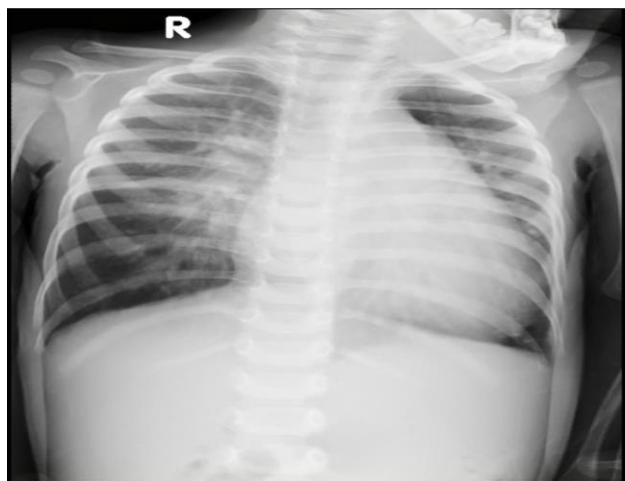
The Chest X-Ray Examination Indicates Cardiomegaly, A Prominently Visible Conus Pulmonalis with Heterogeneous Consolidation in Both Lung Fields Suggests A Condition of Pulmonary Hypertension.
